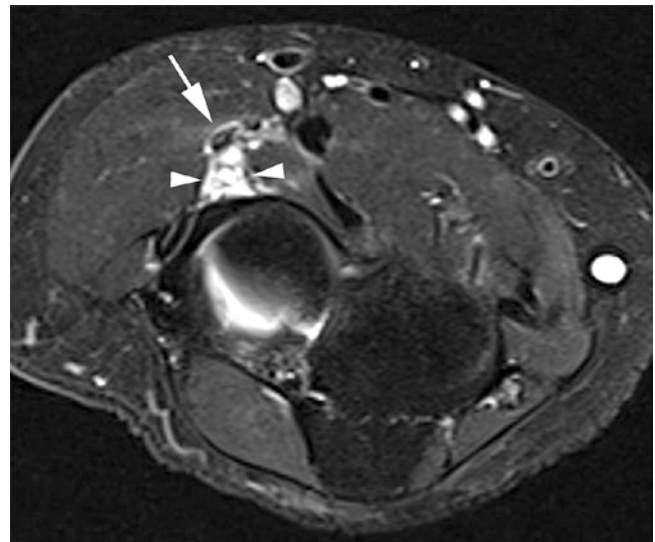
Radial nerve impingement. A 46-year-old female presenting with symptoms of posterior interosseous syndrome. Axial fat-saturated T2-weighted image shows a multilocular ganglion (arrowheads) displacing the deep branch of the radial nerve at that level (arrow)
